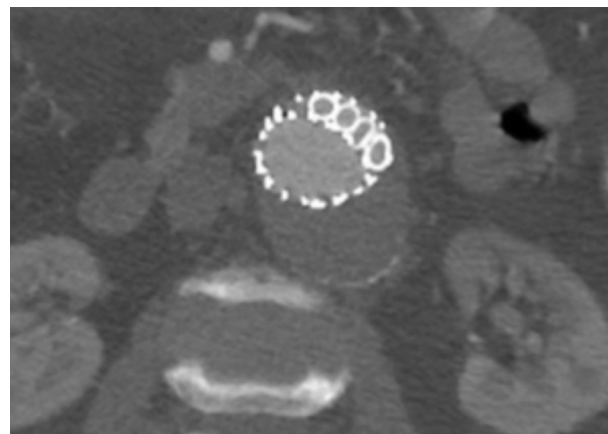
Postoperative computed tomography angiogram indicating zone 5-10 chimney stent graft orientation.
